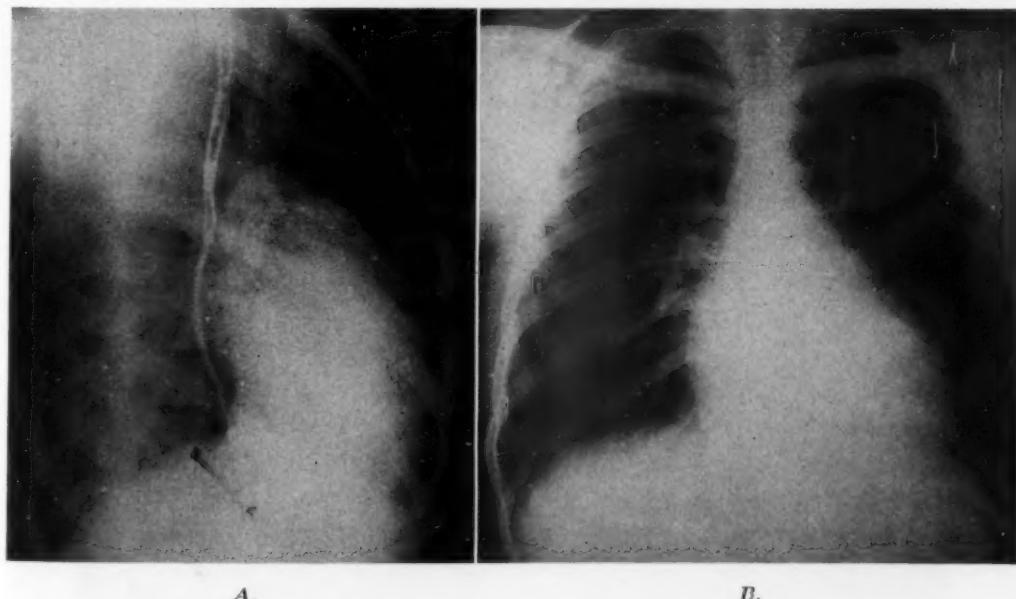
X-ray film of chest of Case 1. A, Right anterior oblique view with barium swallow.
